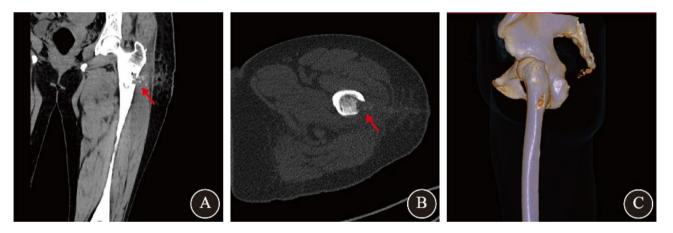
(A) Postoperative coronal CT scan showing the lesion cavity completely filled with allograft bone (red arrow). (B) Postoperative axial CT scan indicating a relatively small surgical channel, and the fenestration length on the tumor surface is close to matches the transverse diameter of the tumor. (red arrow). (C) Postoperative 3D CT reconstruction demonstrating complete filling of the lesion cavity with allograft bone
